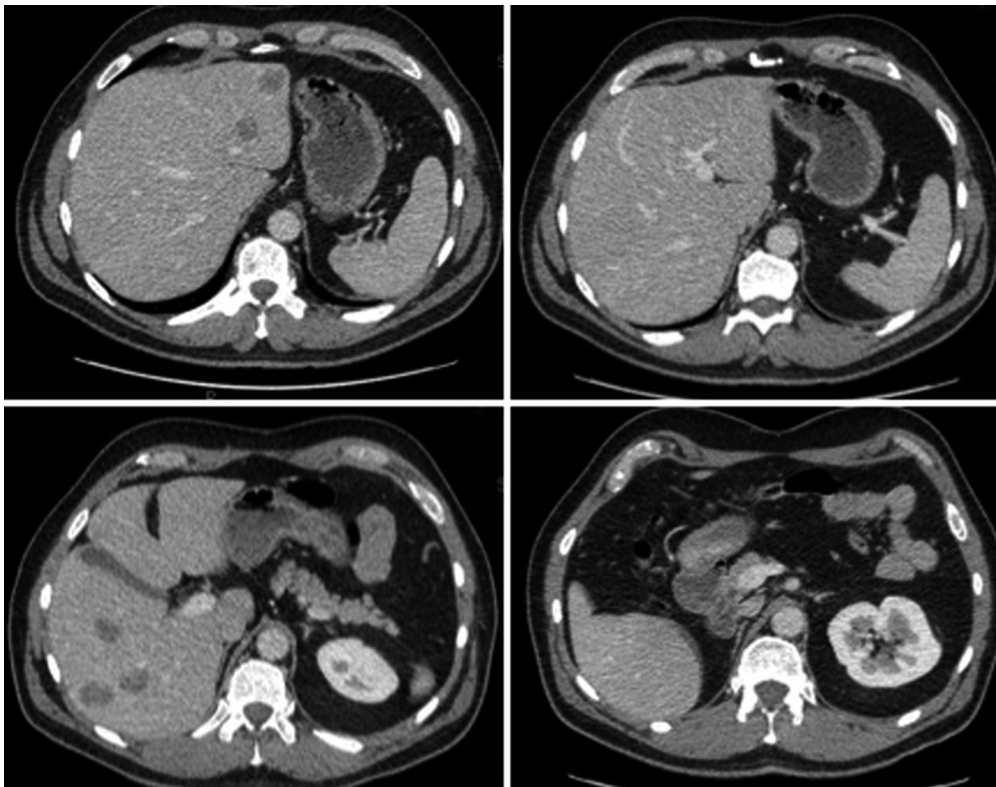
Preoperative triple phase CT liver in patient 2.
